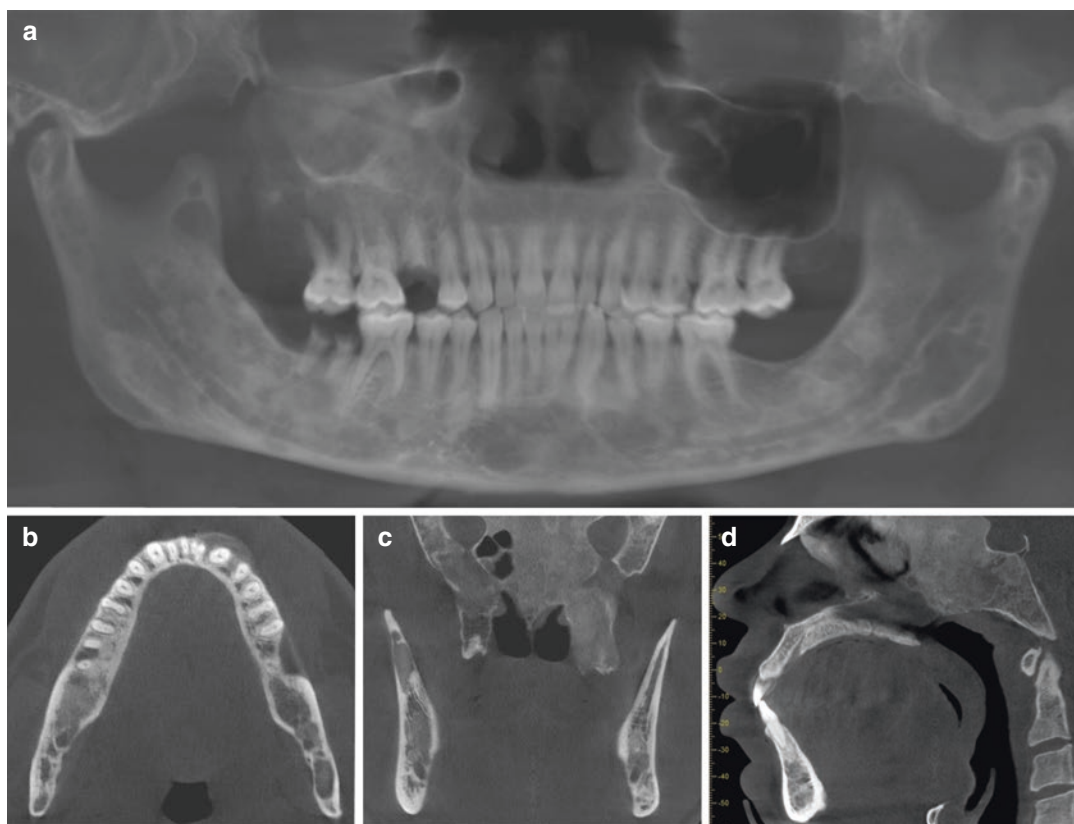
Reformatted panoramic (a), axial (b), and coronal (c) CBCT images showing fibrous dysplasia in the left retromolar area involving the trigone and ramus with characteristic poorly defined margins. There is a little
